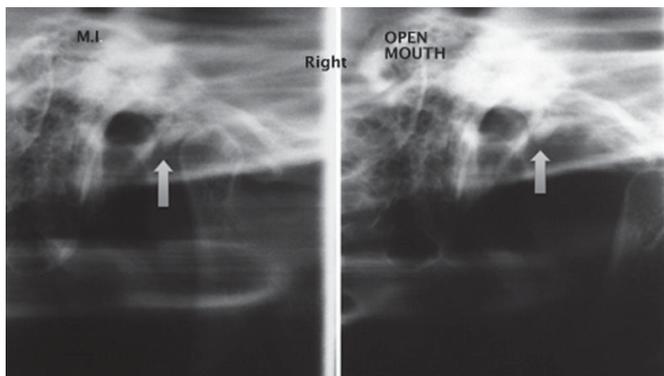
Case 1. Orthopantomograph of right TMJ: Maximum intercuspation (MI) and open mouth. Arrows point to the loose bodies.
